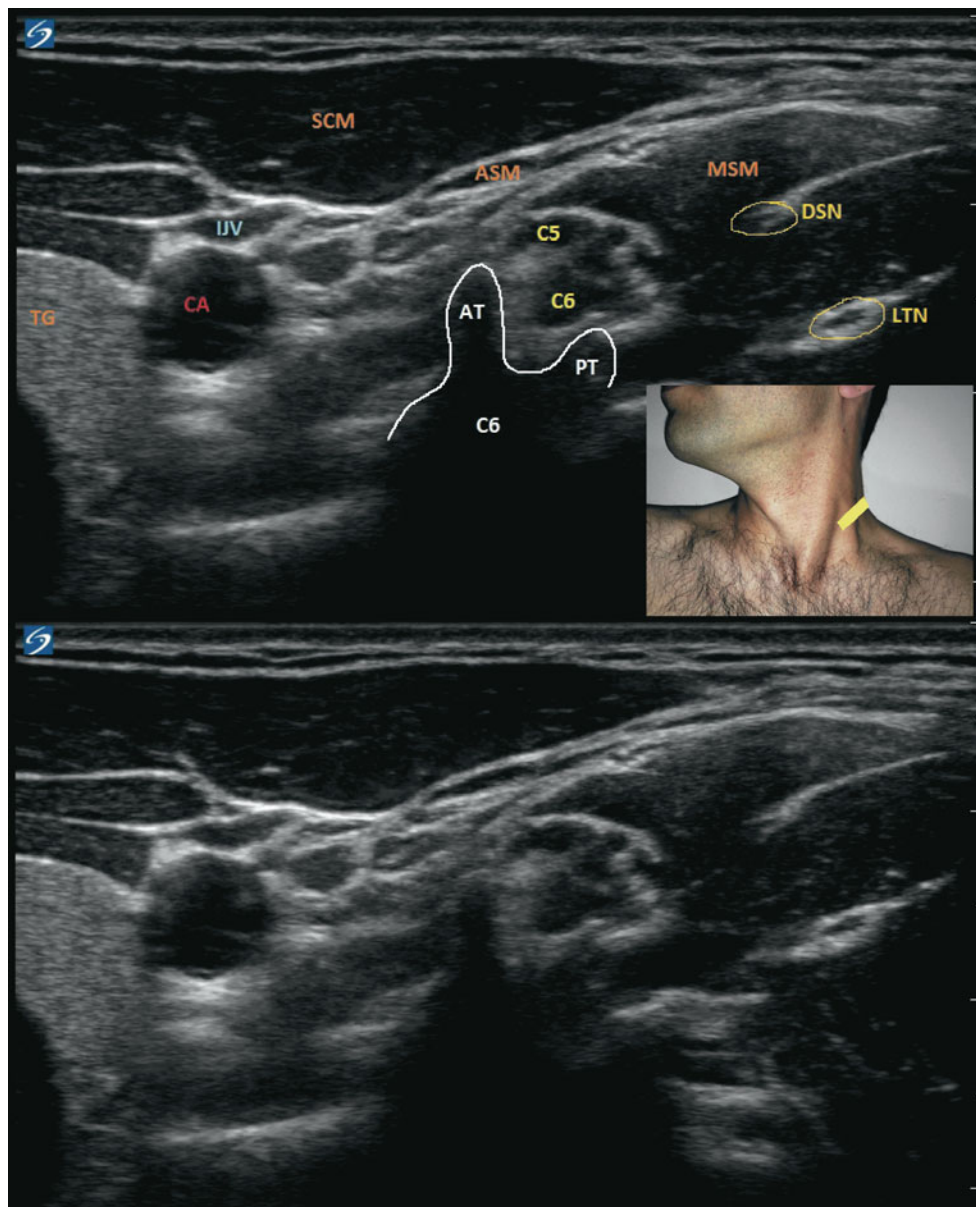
Ultrasound identification of the long thoracic nerve at the middle scalene muscle. *SCM* sternocleidomastoid muscle, *MSM* middle scalene muscle, *ASM* anterior scalene muscle, *TG* thyroid gland, *CA*
